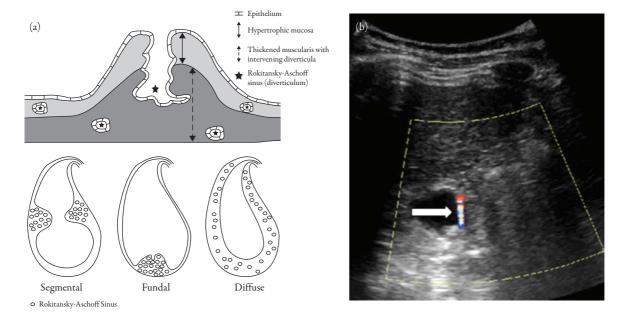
(a) Adenomyomatosis formation and types. While the pathogenesis is not completely understood, there is hyperplasia of the mucosa and muscle layers of the wall. These allow for the formation of diverticula called Rokitansky–Aschoff sinuses that may contain bile, calcifications, or even gallstones (Panel a). The most common type is the segmental type, followed by diffuse and fundal types (Panel b). Adapted from Figures 1 and 3 of Golse N, Lewin M, Rode A, Sebagh M, Mabrut JY. Gallbladder adenomyomatosis: diagnosis and management. J Visceral Surg. 2017;154:345–353. (b) Adenomyomatosis on ultrasound. In addition to irregular wall thickening with visualization of the sinuses and calcifications, there is often ring-down artifact as well as the "twinkling sign" on color Doppler. Adapted from Figure 2 of Hammad AY, Miura JT, Turaga KK, et al. A literature review of radiological findings to guide the diagnosis of gallbladder adenomyomatosis. HPB. 2016;18:129–135.
